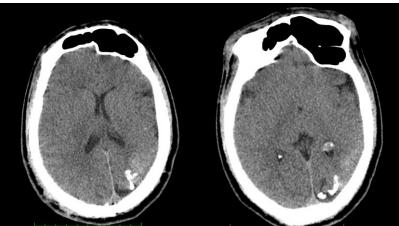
cerebral CT scan without injection of contrast product in axial section showing: left cerebral atrophy, left parietooccipital calcifications, thickening of the choroid plexus with hyperpneumatization of the left frontal sinus
